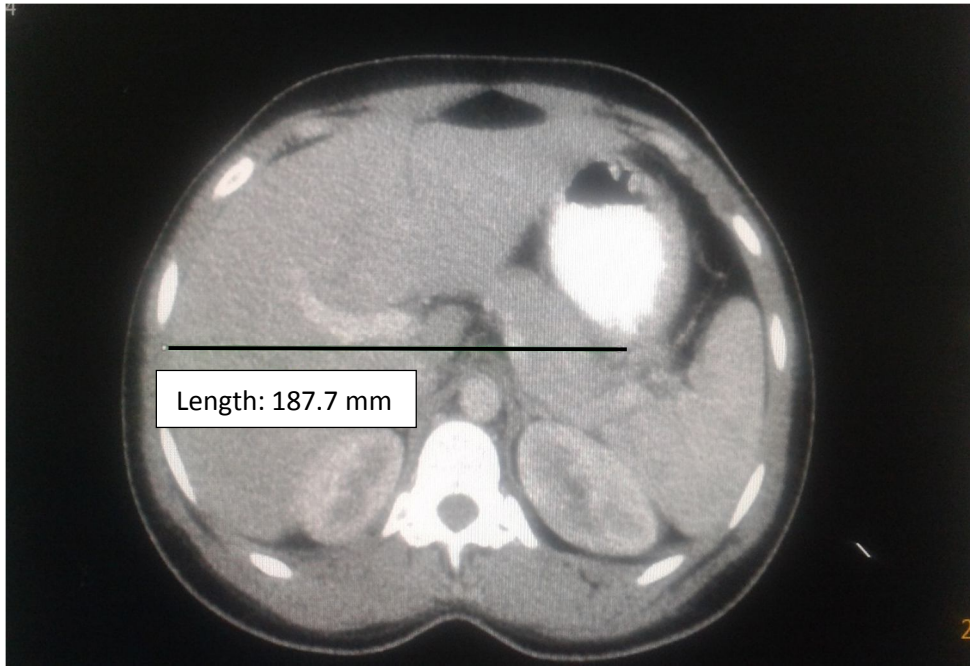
Axial CT image for male (29 years) show measurements of maximum transverse dimension.
